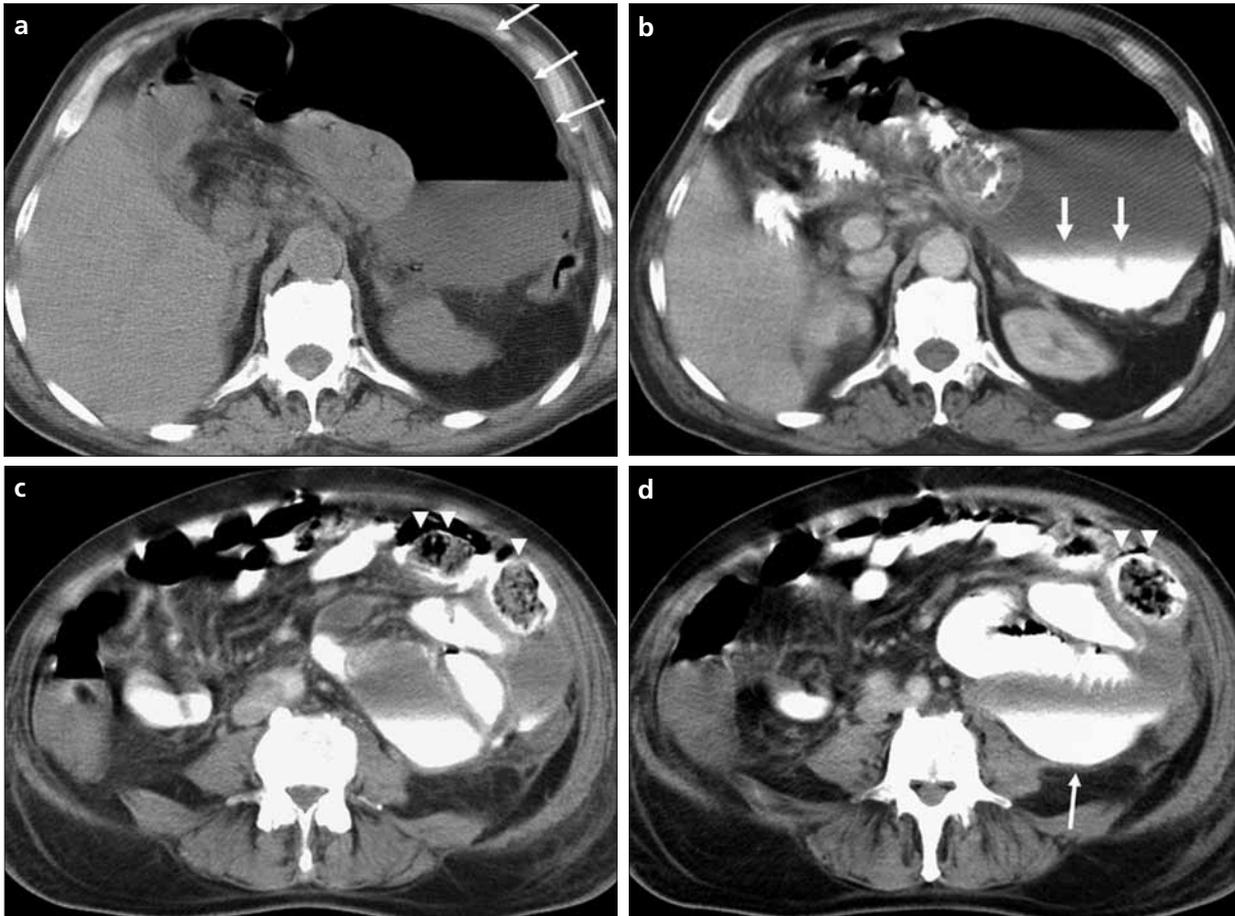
a-d. a. Unenhanced CT scan shows a large area of collection containing air-fluid level (*arrows*). b. CT scan obtained after oral and IV contrast material administration reveals extravasation of contrast to the pouch, which is seen as a contrast-fluid level at this section (*arrows*). c. Additionally, 2 ovoid intraluminal masses with a mottled gas pattern consistent with bezoars are demonstrated (*arrowheads*). d. A consecutive CT section reveals that one of the phytobezoars (*arrowheads*) is located adjacent to the pouch, with contrast-fluid level (*arrow*) draining by a jejunal segment distally.
